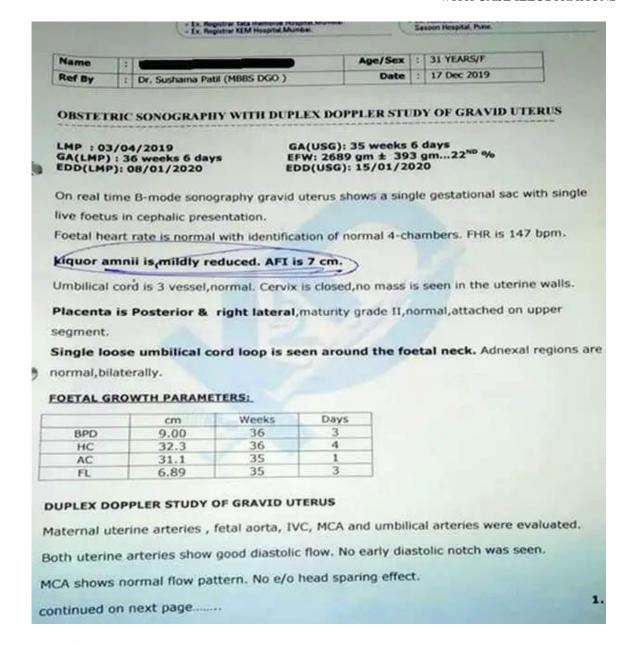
Ultrasonography findings after Homoeopathic Treatment – Case-2
